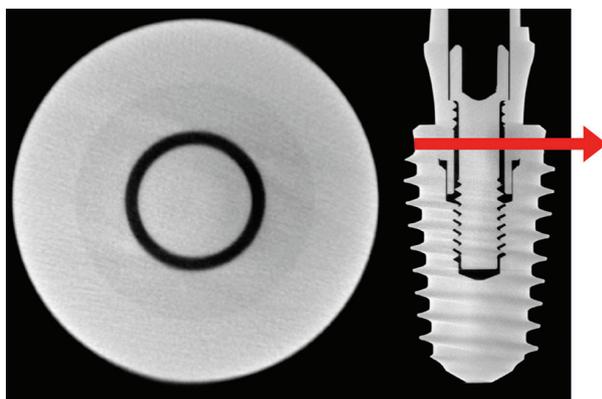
Micro-focus CT of a cone connection with the axial slice shown where indicated in red. No micro-gap can be measured
